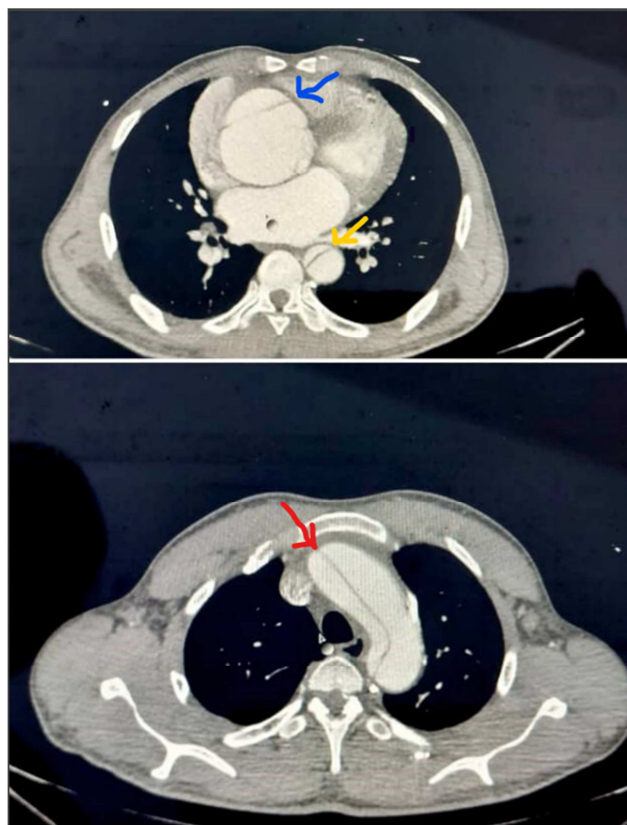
CT image showing type A aortic dissection extending to the abdominal aorta in one of the patients in our study at the CNHU-HKM in Cotonou between 2018 and 2023 (Blue: intimal flap at the level of the ascending thoracic aorta on this CT section passing through T7; yellow: intimal flap at the level of the descending thoracic aorta on this scan section passing through T7; red: intimal flap at the level of the aortic arch on this scan section passing through T4).
